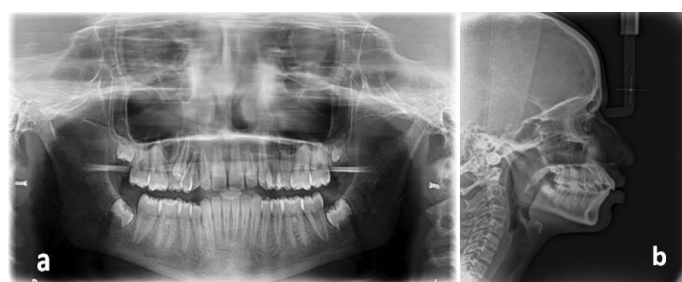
(a) Pre-treatment orthopantomograph (b) Pre-treatment lateral cephalography.
